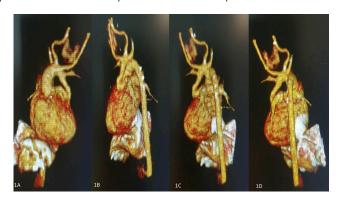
a, b, c, d. Preoperative views of the double aortic arch on computed tomography.
